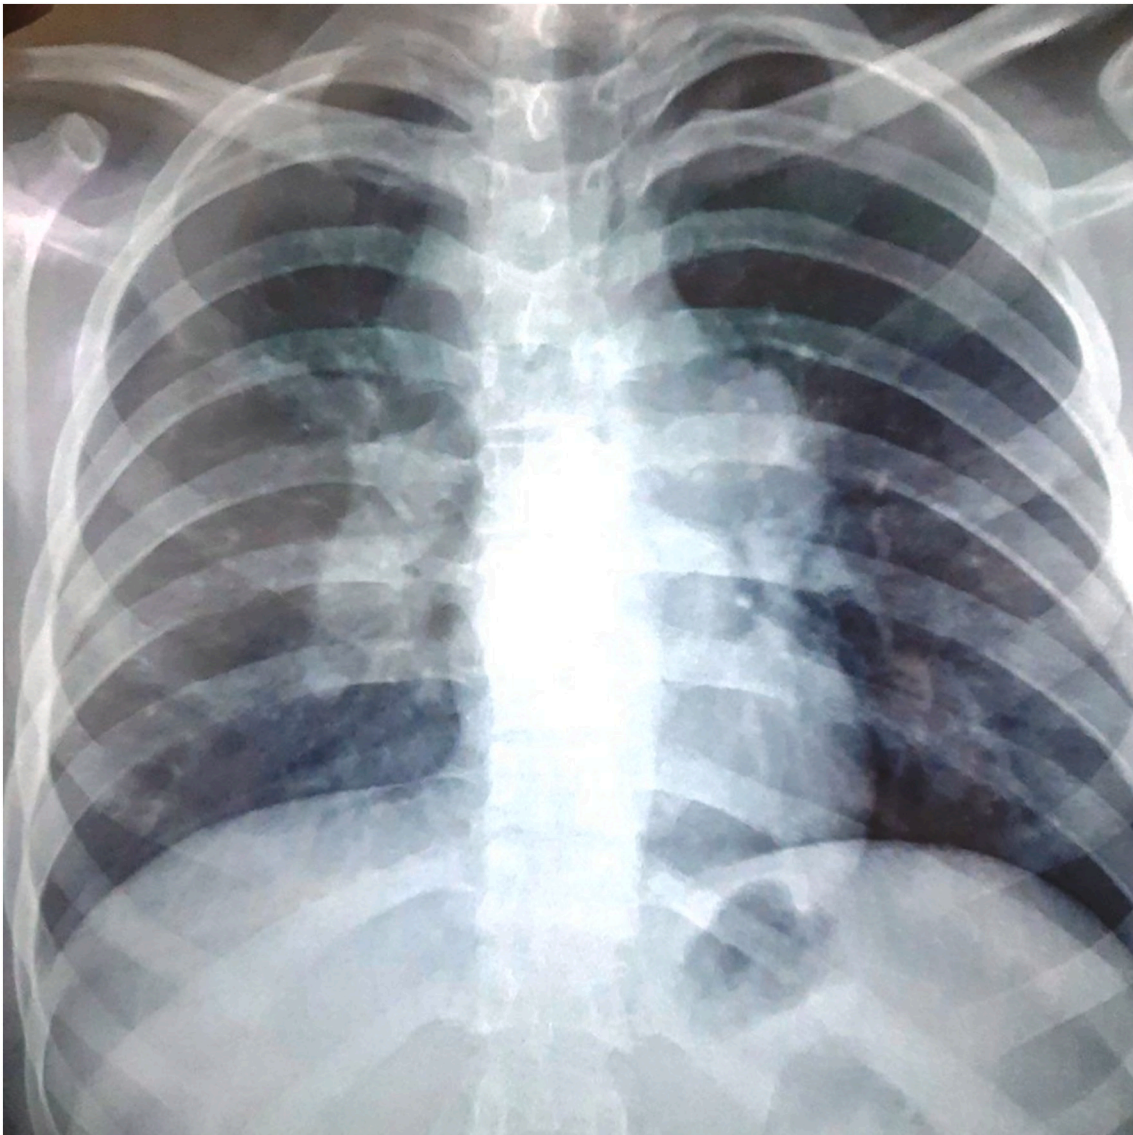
Chest radiograph showing widened mediastinum.
